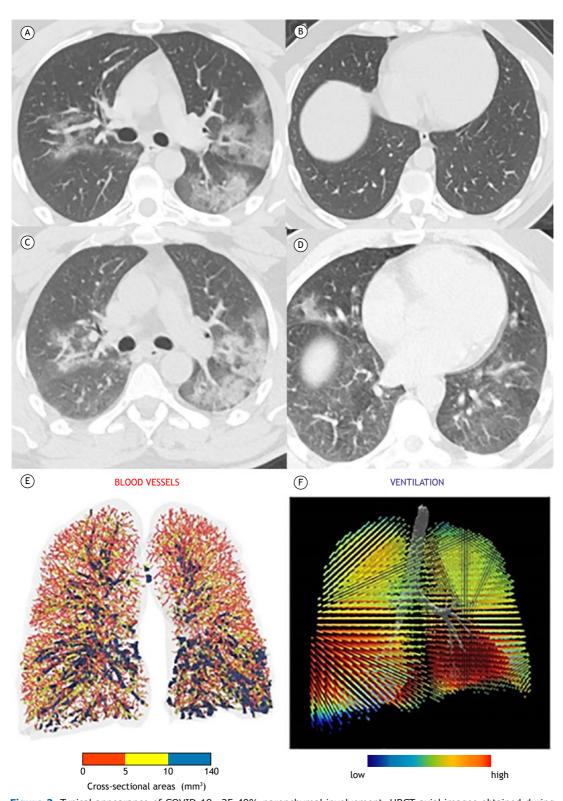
Typical appearance of COVID-19—25-49% parenchymal involvement. HRCT axial images obtained during inspiratory (in A and B) and expiratory (in C and D) acquisitions showing air trapping. In E, three-dimensional visual representation of blood vessels colored according to their size (red, yellow, and blue corresponding to small, mid-sized, and large vessels, respectively). Cross-sectional areas < 5 mm³ are sparse throughout the lung, indicating severe diffuse vasoconstriction even in areas without consolidation. In the ventilation map (in F), most areas of the lung are colored red, representing a normal expansion of lobar volumes between inspiration and expiration, even in areas where there is severe vasoconstriction of small blood vessels.
